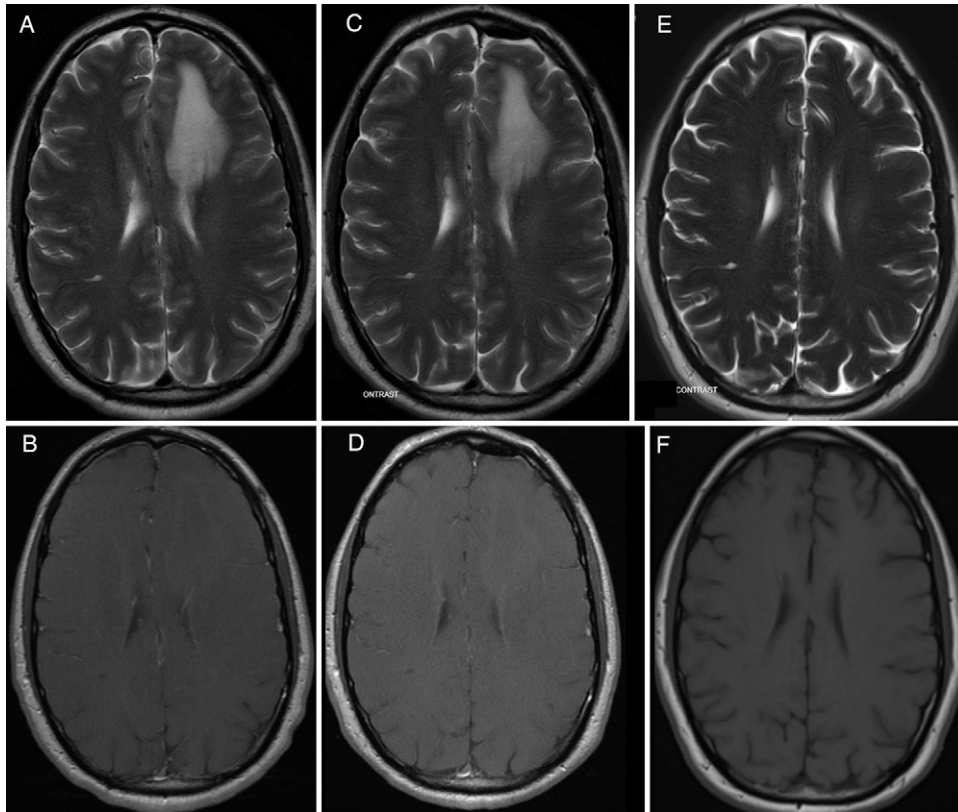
Preoperative T2-weighted MRI with contrast (A) demonstrated a lesion in the left frontal lobe. Preoperative T1-weighted MRI with contrast (B). Postoperative T2-weighted MRI with contrast (C) demonstrating resection cavity, stable mass effect, and vasogenic edema. Postoperative T1-weighted MRI with contrast (D). Three-month postoperative T2-weighted MRI with contrast (E). Three-month postoperative T1-weighted MRI without contrast (F). Gadolinium contrast was utilized where noted.
